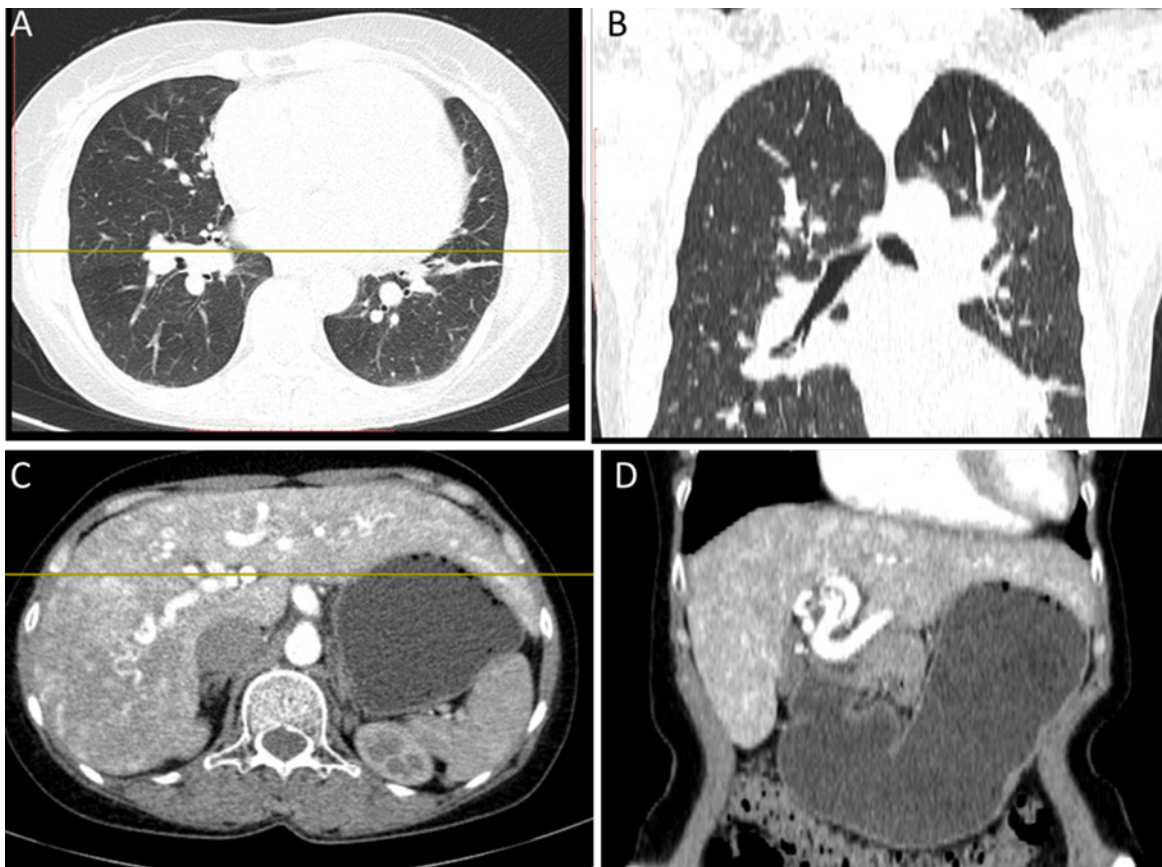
Vascular malformations in visceral organs. Chest CT lung window, axial or a coronal view. Pulmonary vessels are slightly dilated (A, B). Abdominal CT with contrast, axial or coronal view. The hepatic vessels are slightly dilated and curved (C, D)
